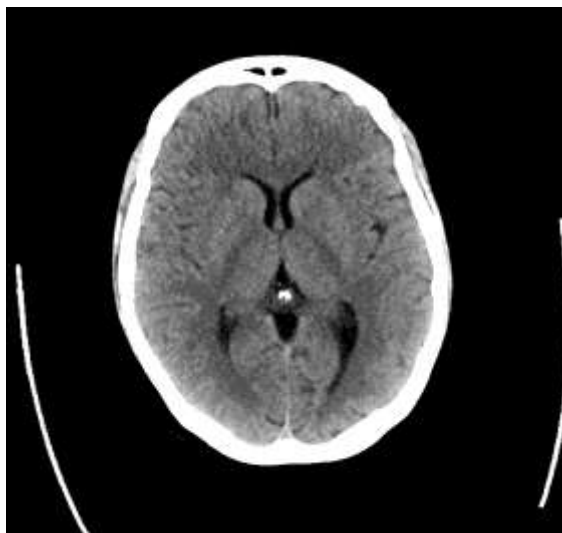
10 normal axial section of CT brain(radiopedia)
